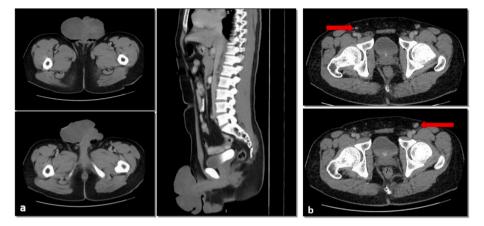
a). Abdominal and Pelvic CT (axial and sagittal) shows tumor mass occupying the region of the penis; b). Right and left inguinal lymphadenopathy.
